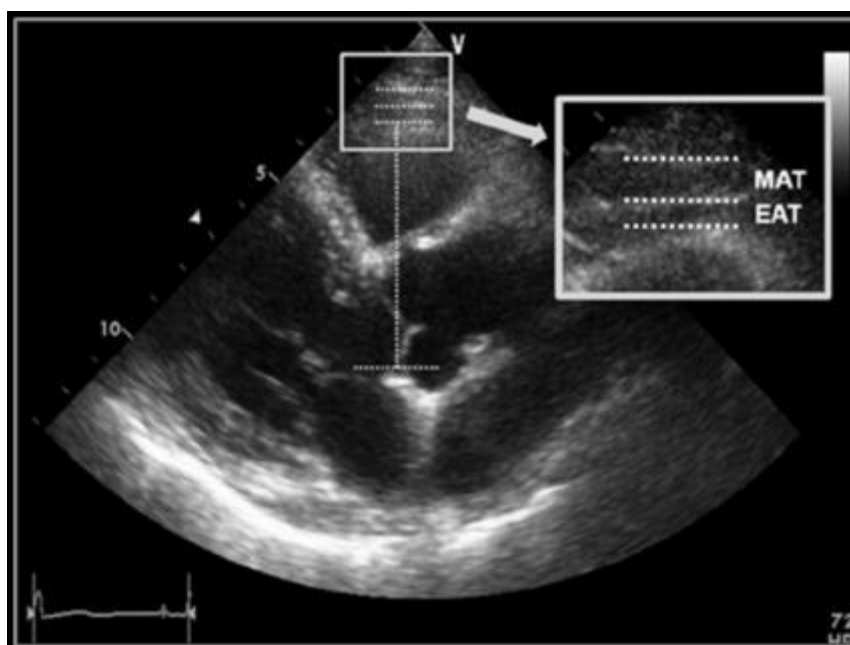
Echocardiographic measurement of EAT and mediastinal adipose tissue [9].
